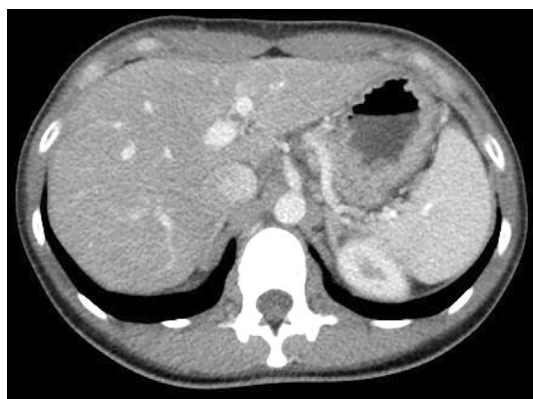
An abdominal contrast enhanced computed tomography scan. There were no signs of liver atrophy, ascites, or dilatation of the bile duct.
